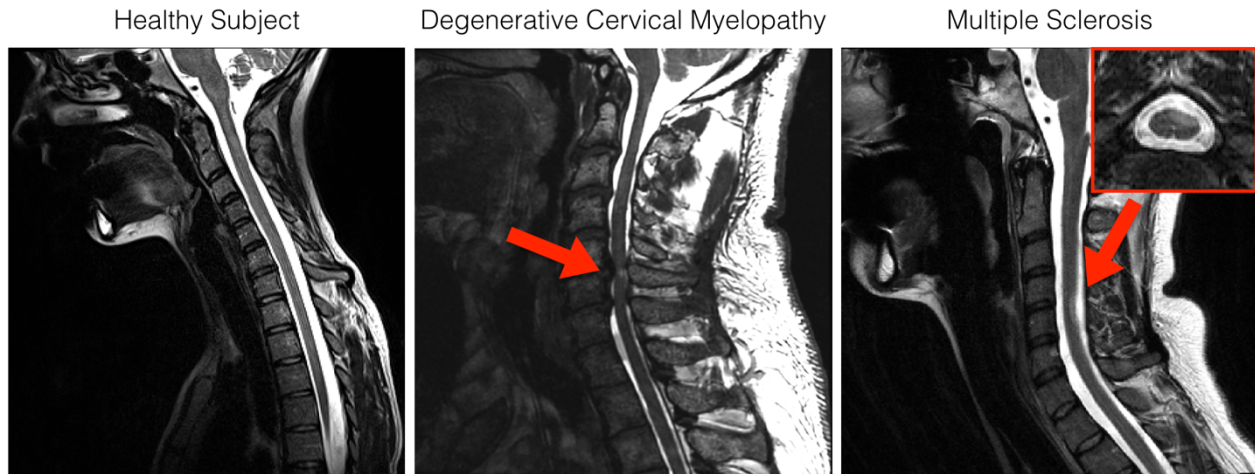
Example of T2-weighted images a healthy subject (left), a patient with Degenerative Cervical Myelopathy (middle) and a patient with Multiple Sclerosis (right). The right arrows highlight the spinal cord lesions.
